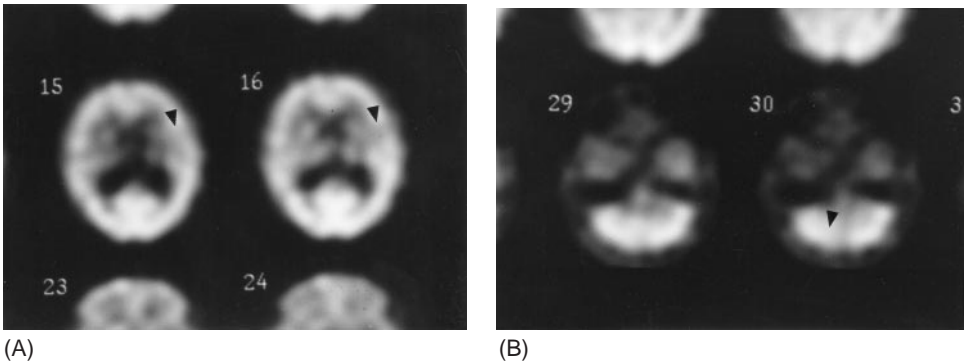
Tc-99m-ECD SPECT scan of the brain performed 9 days after stroke demonstrating (A) a relative hypoperfusion in the left gyrus frontalis inferior and left gyrus precentralis and (B) crossed cerebellar diaschisis.
